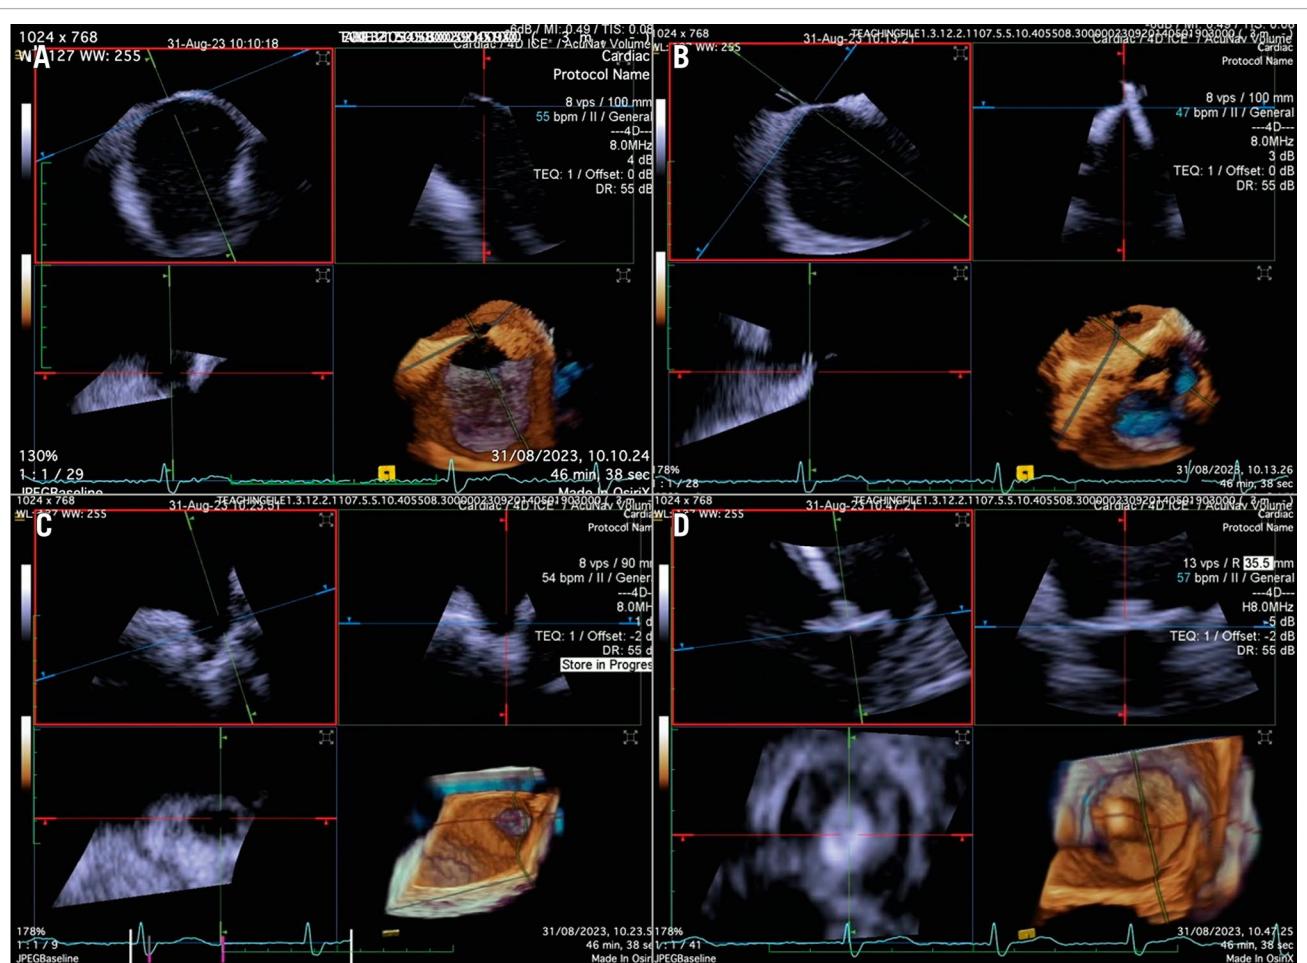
Three-dimensional ICE-guided LAA occlusion. A) 3D MPR with probe in the right atrium to identify the best position of transseptal puncture. B) 3D MPR in real time to assess the catheter crossing the interatrial septum. C) 3D MPR to identify the shape and morphology of the LAA. D) 3D MPR in real time during deployment allows for precise positioning of the device and assessment of the position, anchor, size, and seal. 3D: three-dimensional; ICE: intracardiac echocardiography; LAA: left atrial appendage; MPR: multiplanar reconstruction
